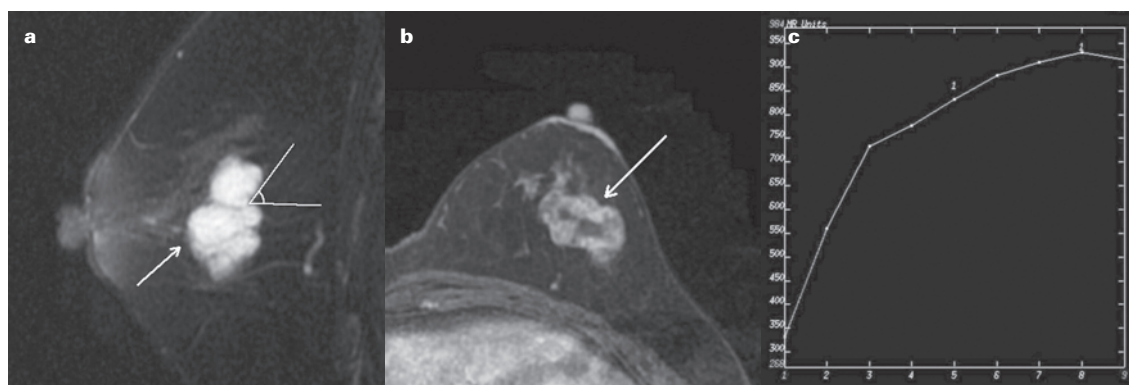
A 59-year-old woman with a pure mucinous carcinoma in her left breast. The irregular mass (arrow) with irregular margin and strong high-signal intensity on the sagittal fat-saturated T2-weighted images (a) shows heterogeneous enhancement (long white arrow) with local rim enhancement (2 short white arrows) and enhancing internal septation (black arrow) in the delayed phase (b) and rapid initial increase enhancement and a persistent enhancement pattern (c).
